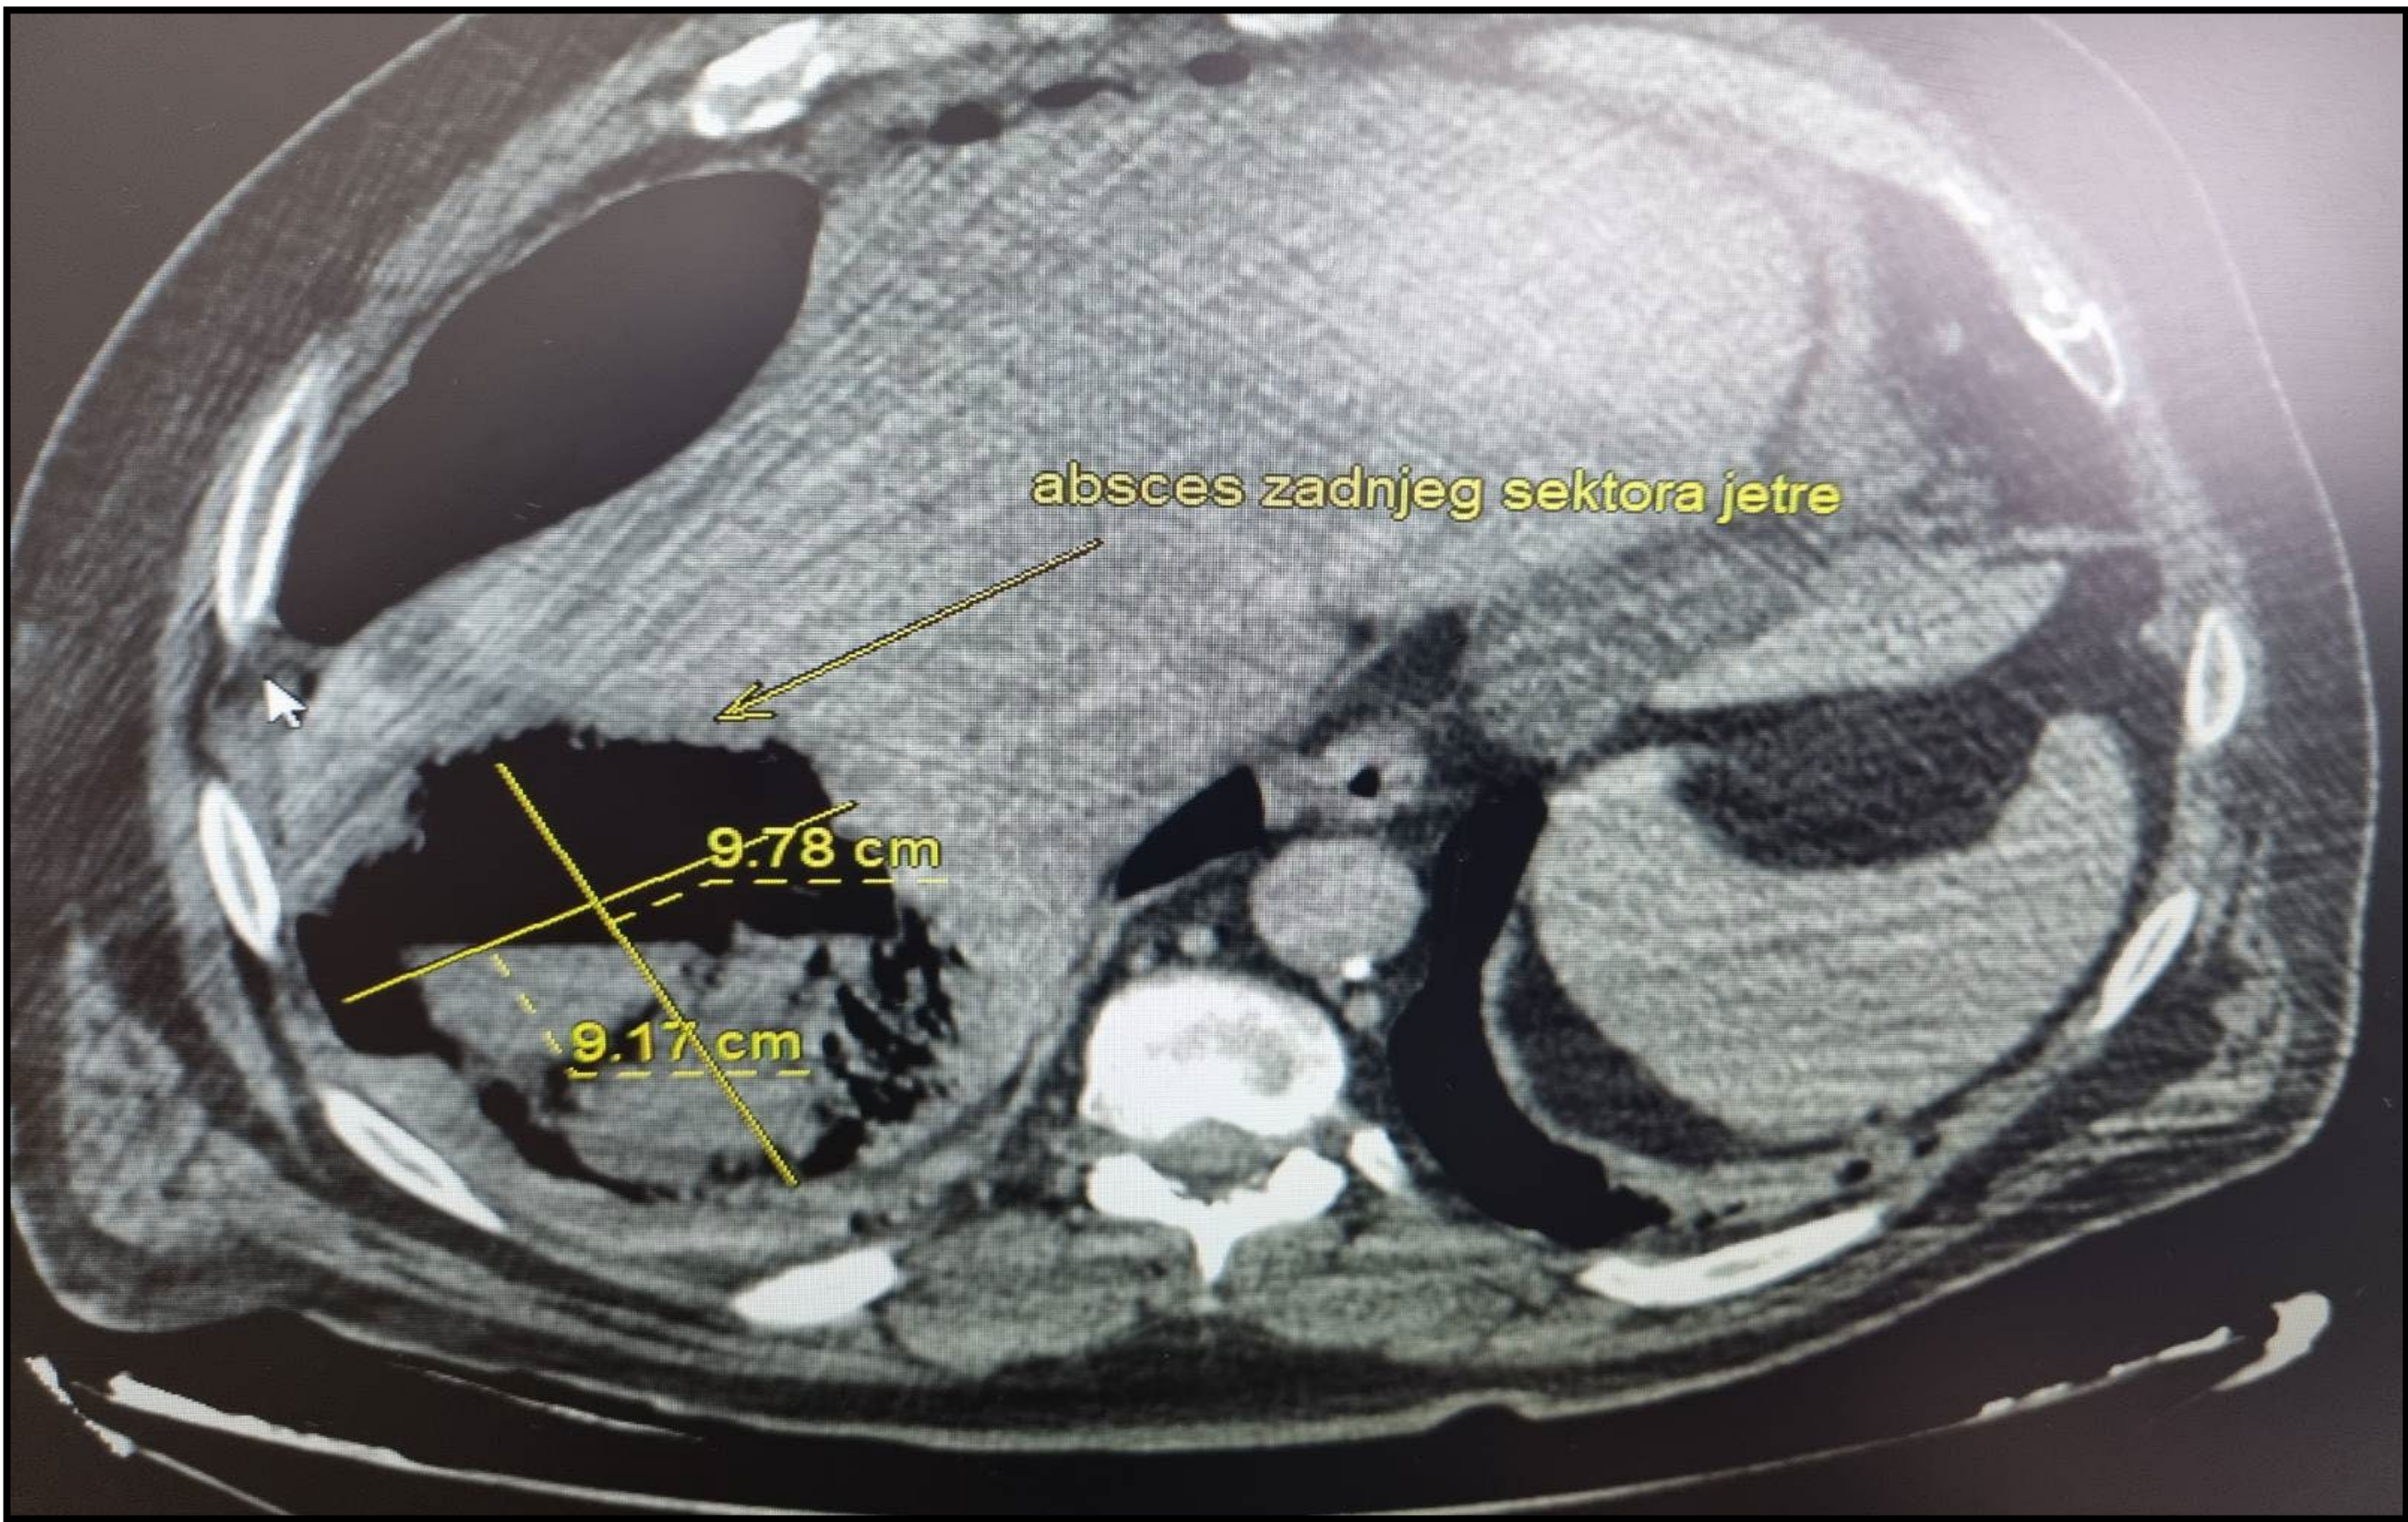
CT of the abdomen and pelvis showing an abscess collection in the posterior sector of the right liver lobe.
